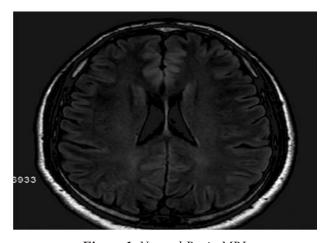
Normal Brain MRI. Axial plane FLAIR sequence
